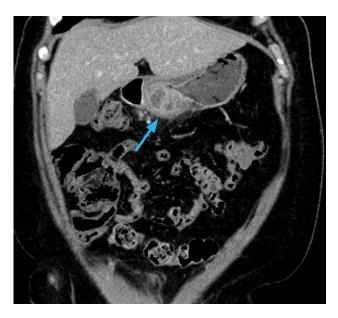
Abdominal CT scan of abscess formation in gastric antrum.
